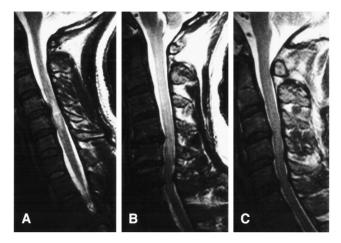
T2-weighted MRIs of the cervical spine and spinal cord in patients 1 (A), 2 (B) and 3 (C).
